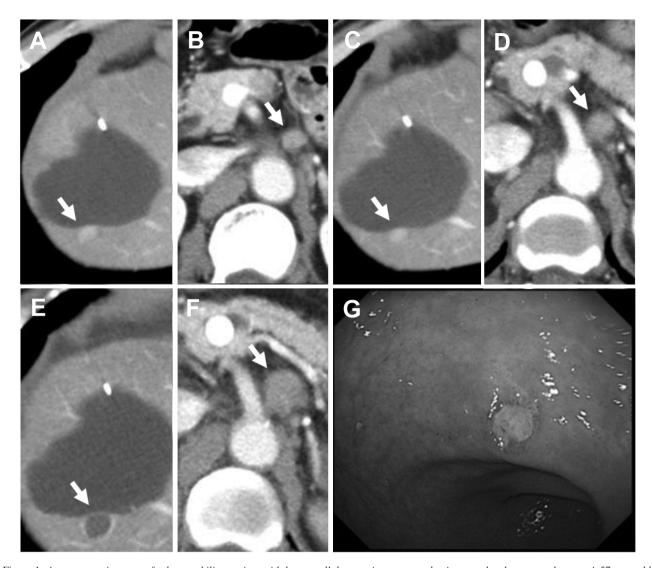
A representative case of a haemophiliac patient with hepatocellular carcinoma treated using a molecular-targeted agent. A 57-year-old male with haemophilia A and hepatocellular carcinoma was administered sorafenib. Abdominal computed tomography performed before sorafenib initiation showed lymph node metastases and intrahepatic lesions (A and B). The antitumour response at 6 weeks was stable disease (C and D). Although the computed tomographic images after 20 weeks of treatment with sorafenib showed an increase in the size of the lymph node metastases, several intrahepatic lesions showed an ischemic antitumour effect (E and F). At 36 weeks of treatment with sorafenib, upper gastrointestinal bleeding was observed (G); therefore, the dose of sorafenib was adjusted, and was continued for 46 weeks after initiation of treatment.
